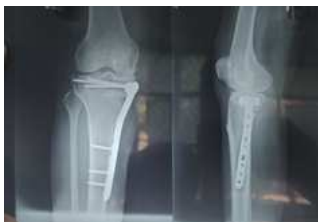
POST-OP X-RAY AFTER 2 MONTHS
